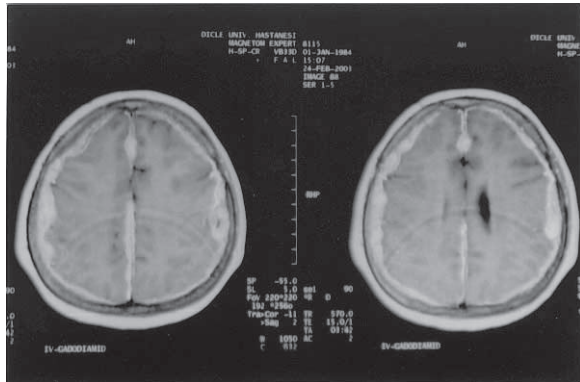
After gadodiamid injection, T1 weighted MRI showed diffuse contrast increased in the meningeal areas surrounding the brain.
